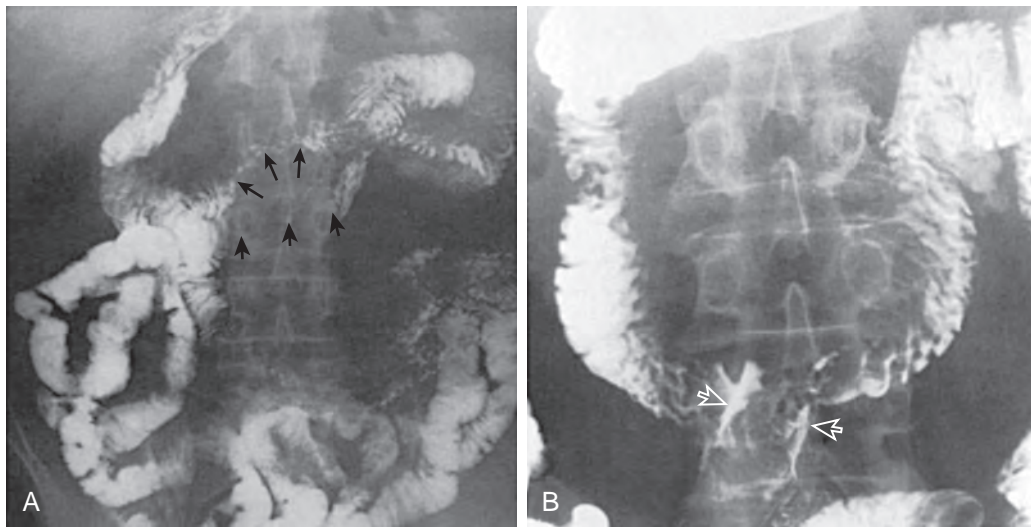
Aortoduodenal fistulas. A. The fistula causes extrinsic compression of the third portion of the duodenum (*thin arrows*) and displacement of an adjacent loop of jejunum (*thick arrows*). No contrast medium is seen entering the fistula. B. In another patient with an aortic graft, extravasated water-soluble contrast medium from the distal duodenum is seen tracking between the graft and aorta (*arrows*). (A from Wyatt GM, Rauchway MI, Spitz HB: Roentgen findings in aortoenteric fistulae. *AJR* 126:714–722, 1976.)
